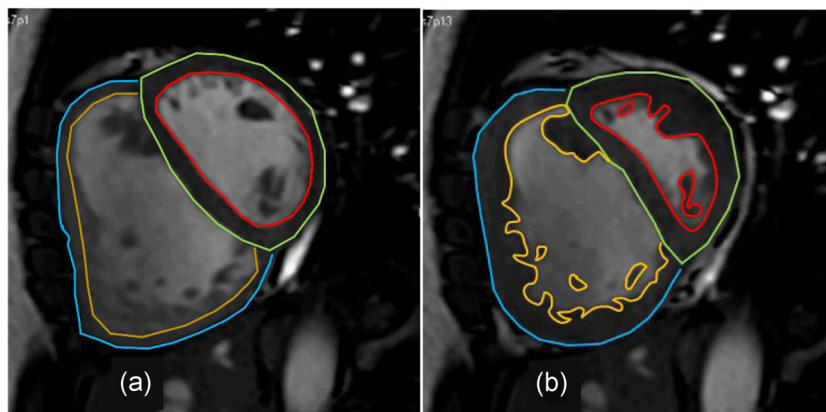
Manual endo- and epicardial contouring of the right and left ventricles in end-diastole (panel a) and end-systole (panel b) from a cine short-axis cardiac magnetic resonance image acquisition in a patient diagnosed with systemic sclerosis-associated pulmonary arterial hypertension. Blue lines mark right ventricular (RV) epicardium; yellow lines mark RV endocardium; green lines mark left ventricular (LV) epicardium; and red lines mark LV endocardium
